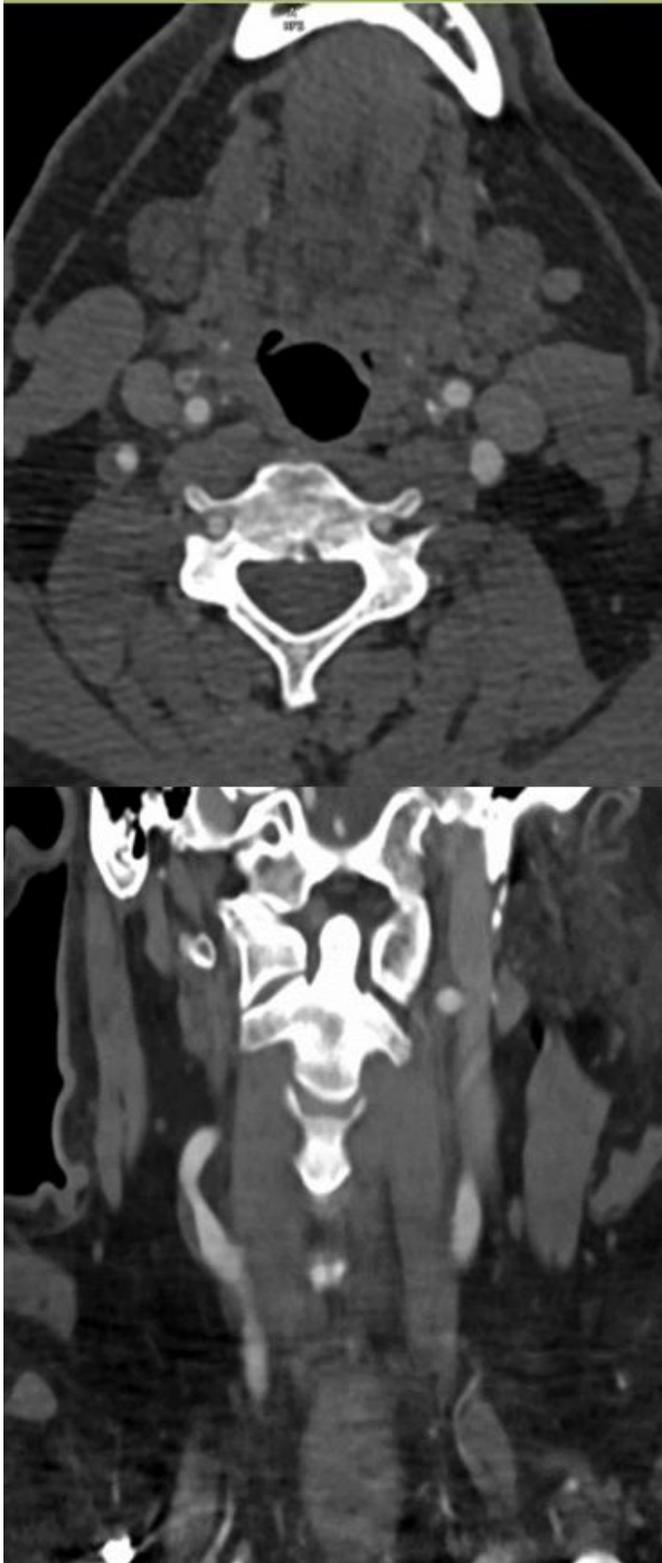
Axial CTA of the neck demonstrating right internal carotid artery stenosis of 50%. Coronal reconstruction CTA of the neck demonstrating right internal carotid artery stenosis of 50%.
